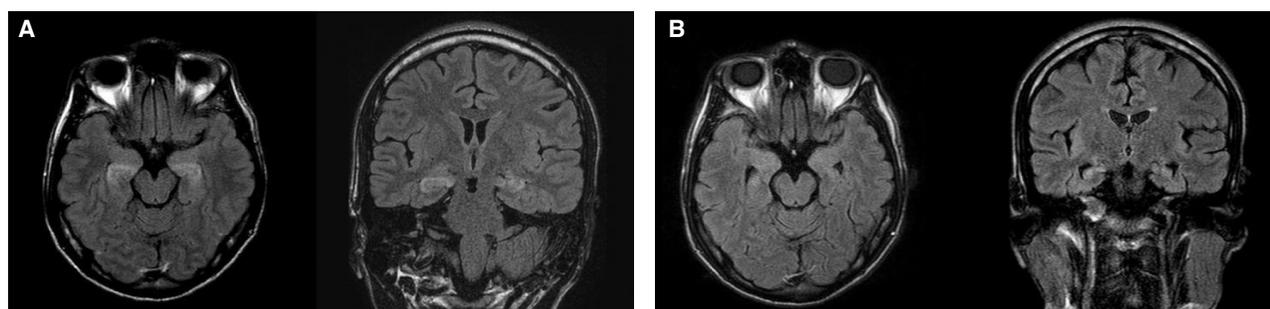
FLAIR images. (A) The initial axial and coronal MRI, three days after admission, show hyperintensities and swelling in the both hippocampi. (B) The follow-up axial and coronal MRI, which were performed forty-five days later, reveal atrophy in both hippocampi.
